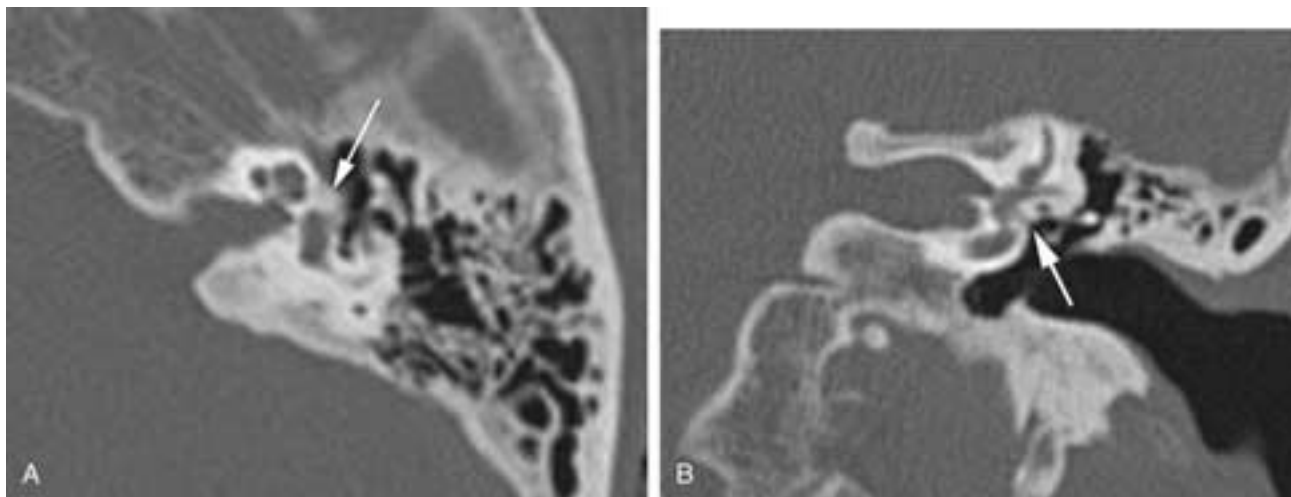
Sclerotic phase of otosclerosis, CT scan. A, The focus of abnormal bone (*arrow*) just anterior to the footplate of the stapes. Note that the bone has almost the same density as the otic capsule. It is also enlarged in size. B, The overgrowth of bone impinges on the oval window (*arrow*) causing significant narrowing. The bone has approximately the same density as the otic capsule.
